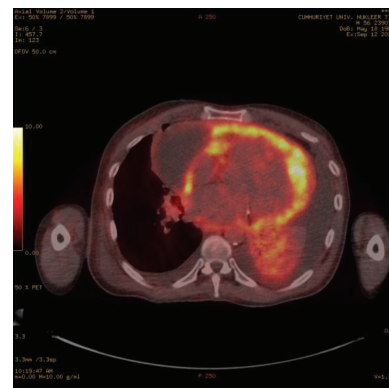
Axial thoracic fusion image of patient in F-18 FDG PET/CT
